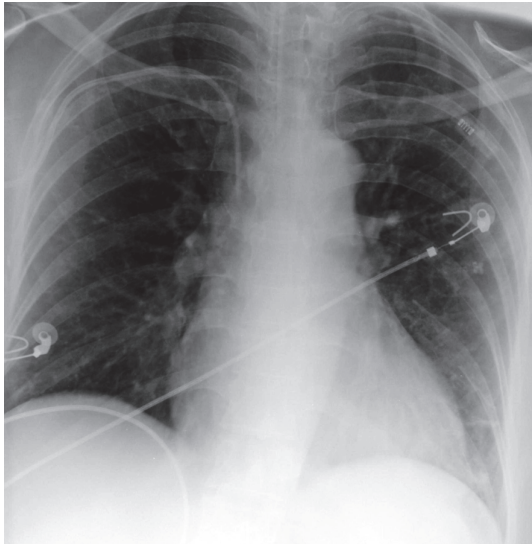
Chest X-ray showing improvement of pulmonary edema.
